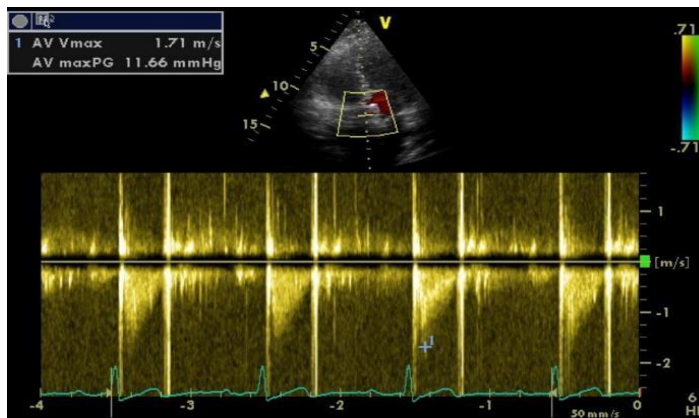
Echocardiography performed in 2018, three years after ESMR.
